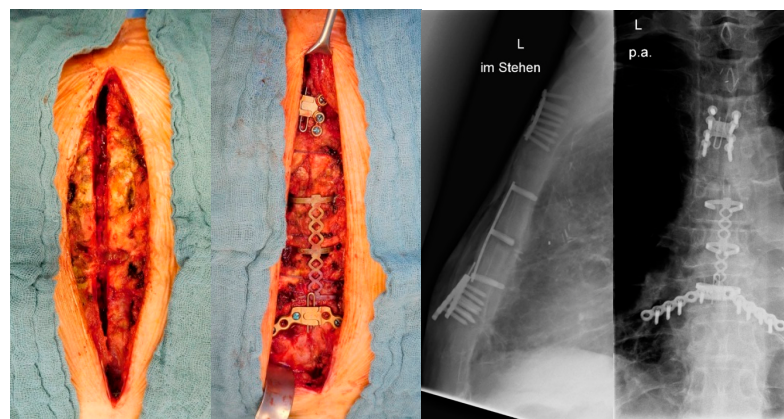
Osteosynthesis for grade II with a transverse fracture bridged using a clip. (Left) Intraoperative situs before and after osteosynthesis. (Right) Postoperative two-plane chest X-ray.
